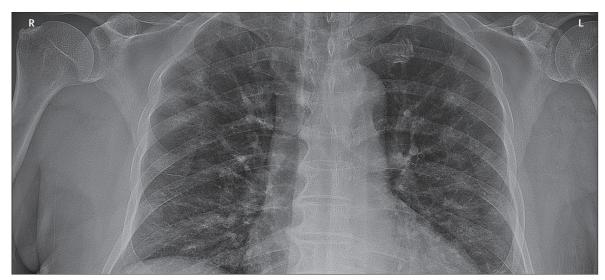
First case of 2019 novel coronavirus in Canada Chest x-ray shows bilateral, peribronchovascular, ill-defined opacities in all lung zones.
